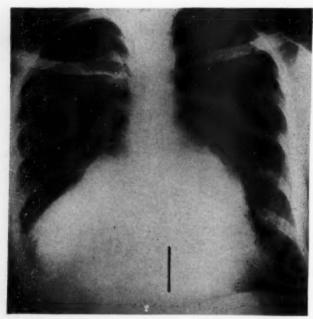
Chest roentgenogram of patient L. R. with stenosis and insufficiency of tricuspid and mitral valves. Right atrium is of giant size; left atrial appendage bulges prominently along left border of heart. Line drawn within cardiac silhouette indicates location of tricuspid valve as defined by angiocardiogram.
